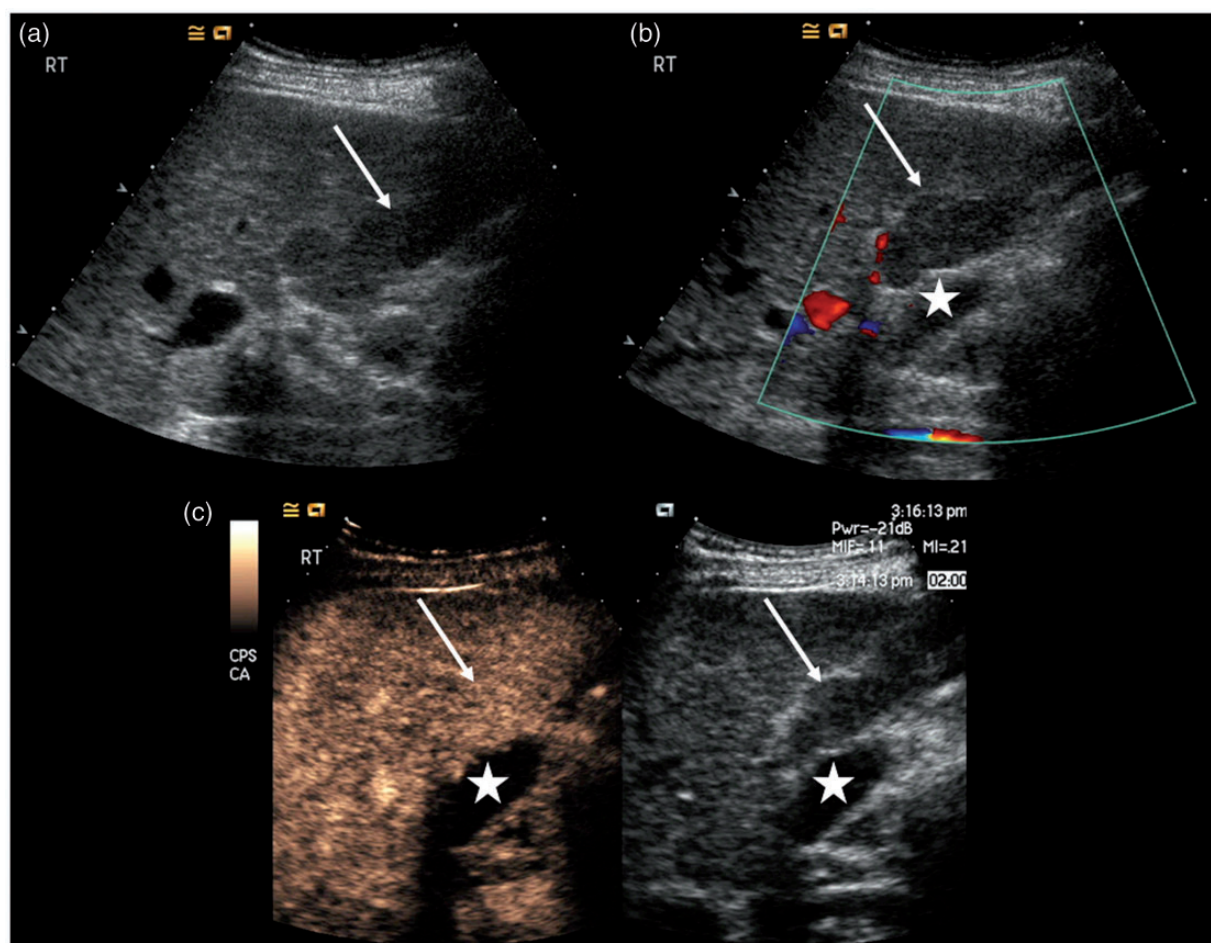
Focal fatty sparing on: (a) grey scale, (b) colour Doppler and (c) CEUS (arrow = focal fatty sparing, star = gallbladder fossa). Focal fatty sparing is isoechoic to background liver on administration of ultrasound contrast (c)
